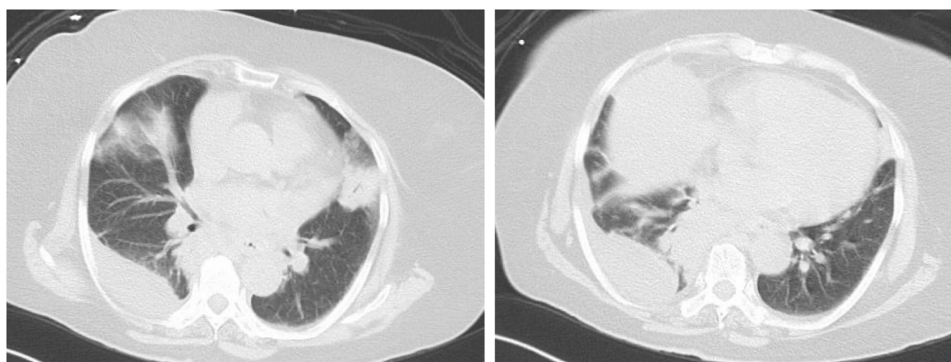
A chest CT scan in Case 2 shows irregular consolidations, ground glass opacity and bilateral pleural effusion.
